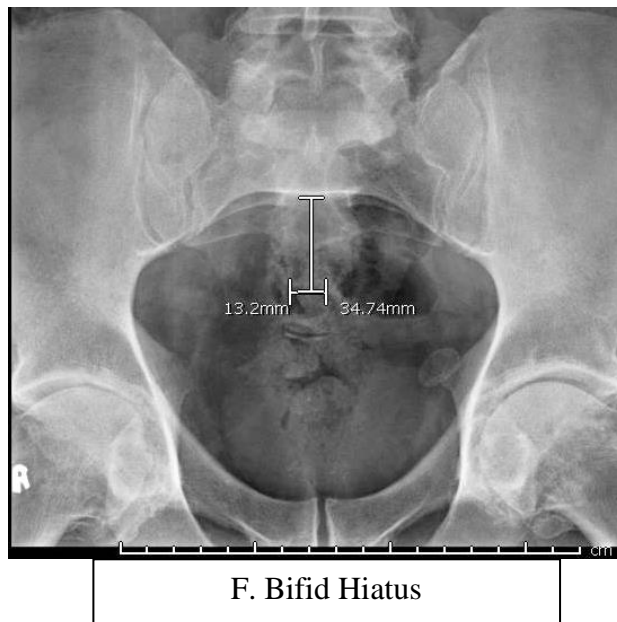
X-ray of LS Spine AP view showing the hiatal shapes observed; A: Inverted V; B: Inverted U; C: Irregular; D: Dumbbell; E: M-shaped; F: Bifid (Courtesy of Advanced Radiology Clinic, Karachi)
